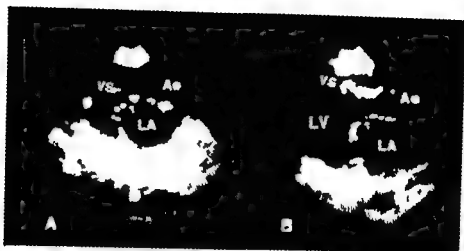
The left ventricular longitudinal cross sectional echocardiographic view in panel A represents severe doming of the anterior mitral valve leaflet (small white arrow). The ventricular septum (VS), aorta (Ao) and left atrium (LA) are also shown. Panel B demonstrates mild to moderate anterior mitral valve leaflet doming.
